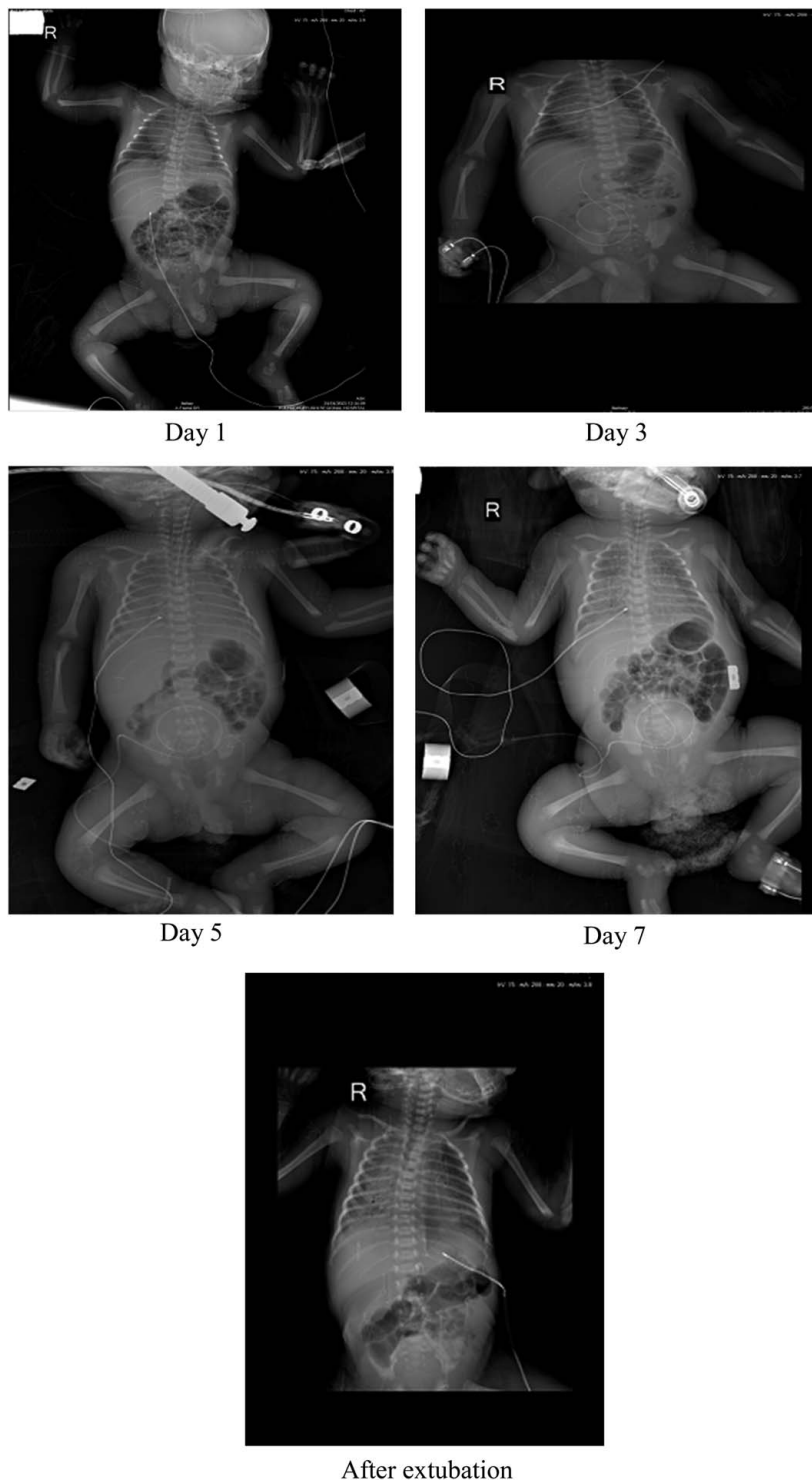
Serial chest radiographs (anteroposterior view) showing gradually improving bilateral pneumonia.
